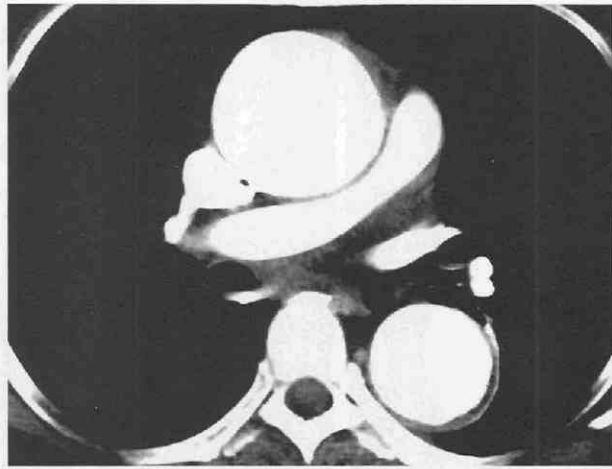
Axial CT scan demonstrates an aneurysm of the ascending aorta in a patient presenting with acute chest pain.
